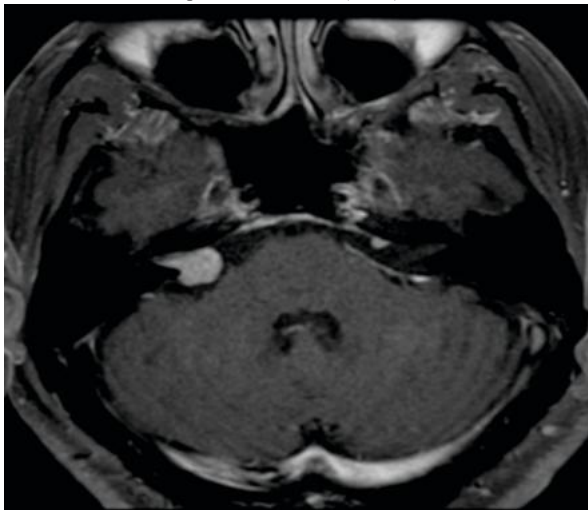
MRI Showing Vestibular Schwannoma.
